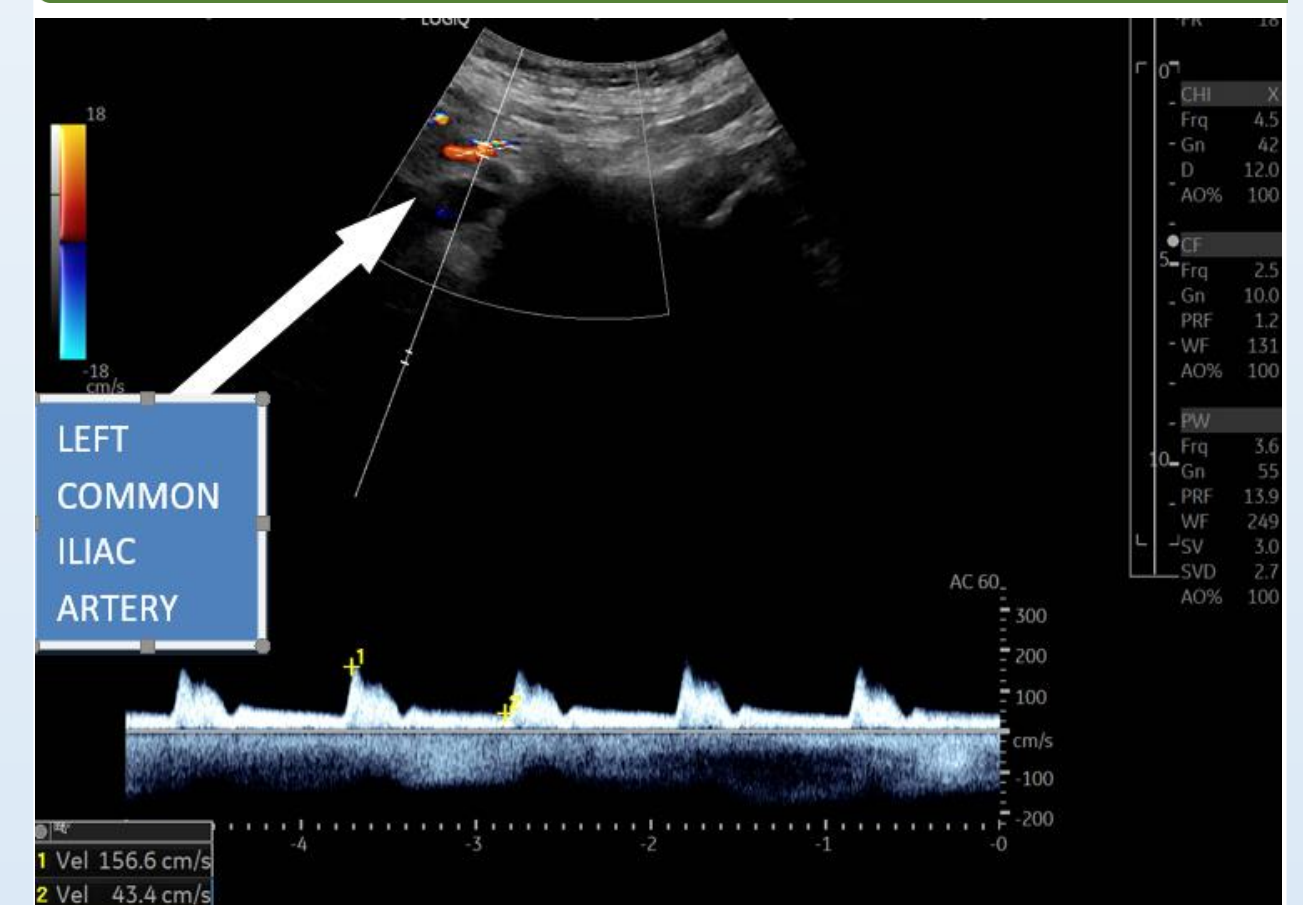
Spectral Doppler of the left common iliac artery indicating a peak systolic velocity of 157 cm/s.
